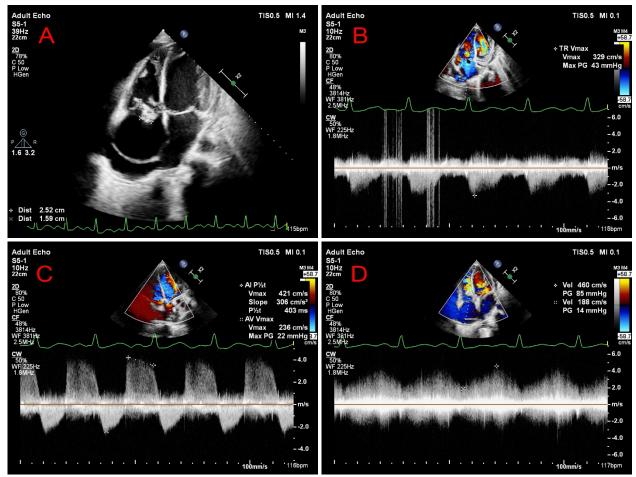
TTE images. A) Apical four chamber (A4C) view demonstrating mass of size 25 x 16 mm around tricuspid valve with borderline enlargement of right atrium and right ventricle, and mild pericardial effusion; B) CW doppler across tricuspid valve demonstrating moderate TR with maximum pressure gradient of 43mmHg; C) CW doppler across aortic valve demonstrating mild eccentric AR with pressure half time (PHT) of 403ms; D) CW doppler across tricuspid valve demonstrating and 14mmHg respectively.
